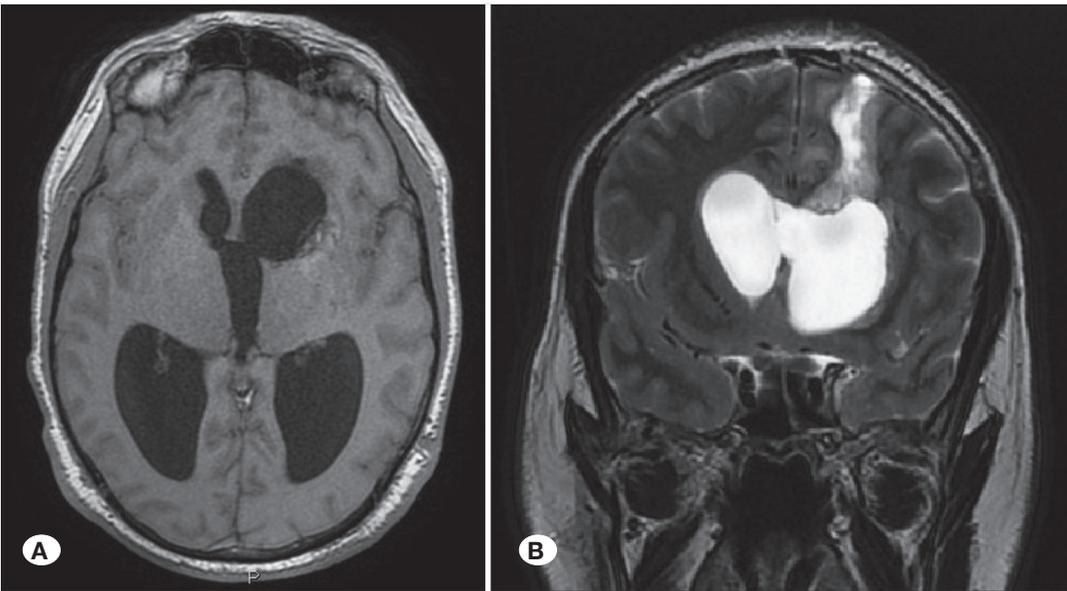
Case 1 - intraventricular ganglioglioma. Postoperative T1W axial (A) and T2W coronal (B) MRI scans showing: complete resection via transcortical approach.
